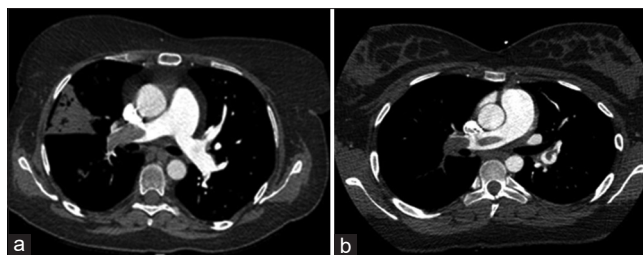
Transverse computed tomography images (a) and (b); multidetector computed tomography scans of chest obtained with the standard protocol of CM-injection (a) and individualized protocol of CM-injection (b)
